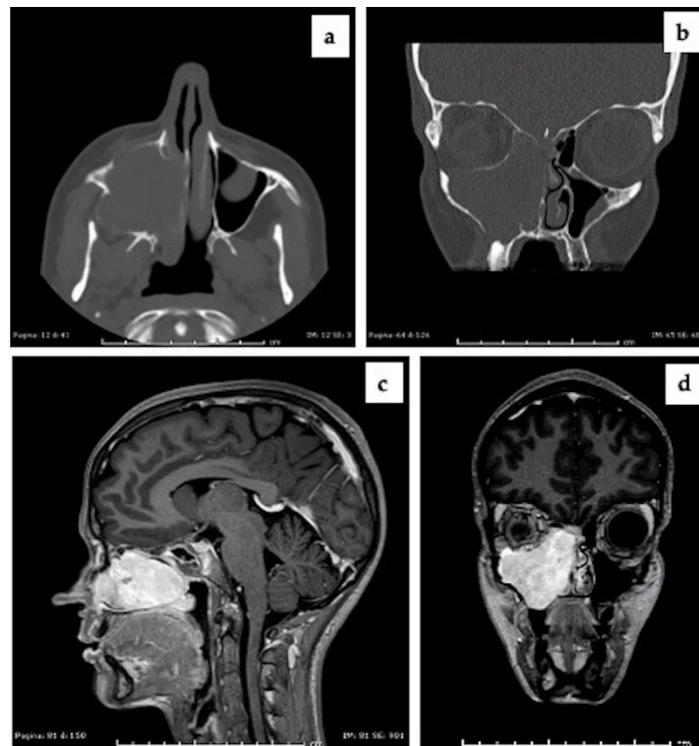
Preoperative imaging. (a) CT, axial view; (b) CT, coronal view; (c) MRI, sagittal view; (d) MRI, coronal view.
